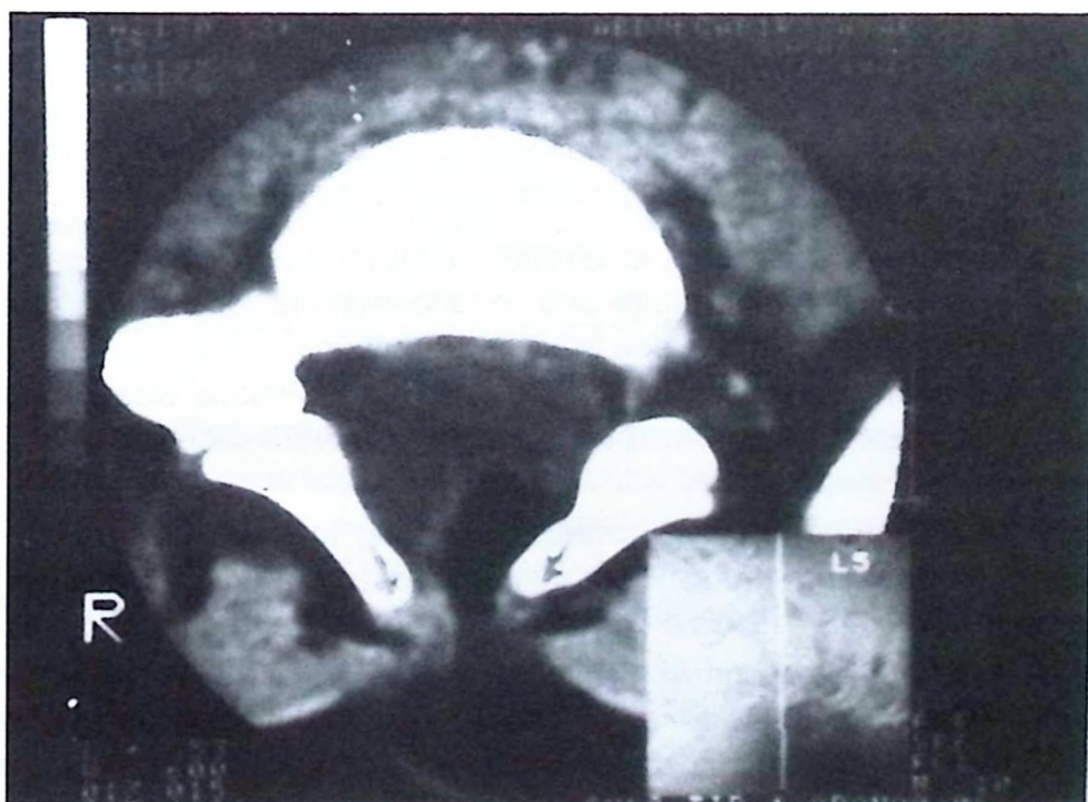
Epidural lipoma, with extraspinal invasion, on computed tomography.
